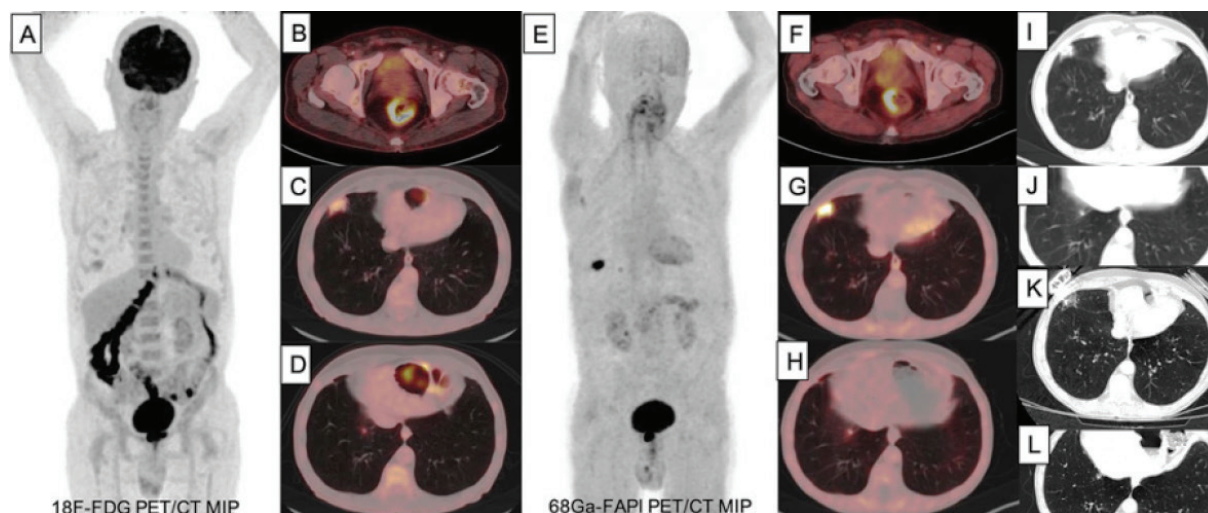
A 70-year-old man presented with changes in defecation habits and hematochezia. Colonoscopy showed tumor in the rectum and biopsy was confirmed as adenocarcinoma. Patient was referred to ¹⁸F-fluorodeoxyglucose positron emission tomography/computed tomography (¹⁸F-FDG PET/CT) for staging. After 6 hours of fasting 222 MBq ¹⁸F-FDG was injected intravenously. PET/CT was performed after 1 hour of distribution time. The primary tumor in the rectum with intense ¹⁸F-FDG uptake [maximum standardized uptake value (SUV_{max}): 17.9] along with diffuse colonic uptake (SUV_{max}: 28.9) was observed on PET/CT (A, B). In addition, there was increased ¹⁸F-FDG uptake at consolidation area and subsantimetric nodular lesion in the anterior segment of the right upper lung (SUV_{max}: 4.5) (C, D). ⁶⁸Ga-fibroblast activation protein inhibitor (FAPI)-04 PET/CT was performed after 155.4 MBq ⁶⁸Ga-FAPI-04 injection after 1 hour in the same week with ¹⁸F-FDG PET/CT, for an ongoing clinical trial. ⁶⁸Ga-FAPI-04 PET/CT showed intense uptake at the rectal tumor (SUV_{max}: 14.8) without inflammatory colonic uptake and at lung lesions (SUV_{max}: 12.2) (E, F, G, H, I, J). Lung lesions with both increased ¹⁸F-FDG and ⁶⁸Ga-FAPI-04 uptake were suspected for lung metastases of rectum cancer. After antibiotherapy for 20 days, it was seen that the lesions were resolved and reduced in size on thorax CT and diagnosed as pneumonia (K, L). ⁶⁸Ga-FAPI PET/CT has been the subject of increasing research in recent years with its success in tumor imaging (1). Fibroblast activation protein is over-expressed on cancer-associated fibroblasts and also in tissue remodeling sites associated with fibrosis, cirrhosis, atherosclerosis, cardiac injury, and pneumonia (2,3,4,5,6). Although ⁶⁸Ga-FAPI PET/CT is reported to be superior to ¹⁸F-FDG PET/CT for detecting metastasis and primary tumor due to high tumor/background ratio and absence of inflammatory colonic ¹⁸F-FDG uptake as in our case, the reasons for false positives should be also kept in mind (7,8).
